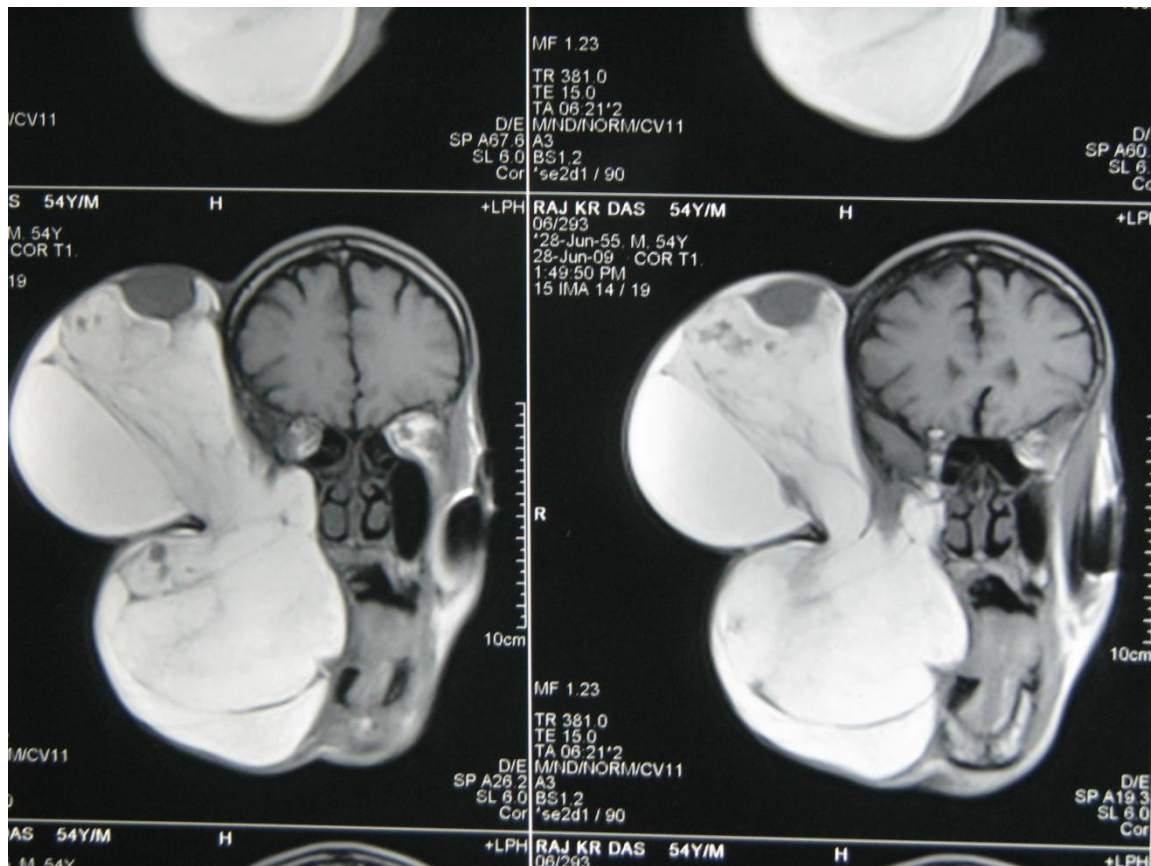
MRI showing large heterogeneous bilobed mass on right side of face
